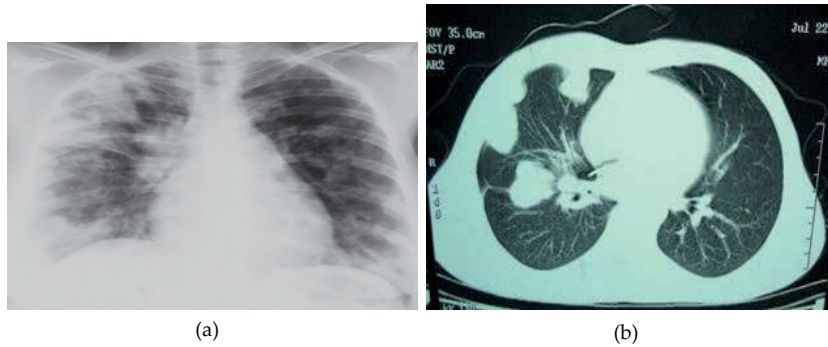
(a) Chest radiograph demonstrates multiple peripheral round areas of soft-tissue opacity.(b) CT scan shows a clearly defined capsule with a relatively hypo attenuating center, a finding that reflects the cystic nature of the lesions.
